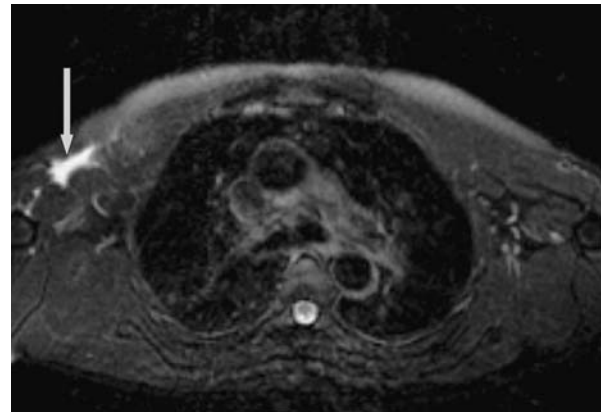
Axial T2-Fat Saturated Image of both shoulders. The discontinuity of the pectoralis muscle is seen on the right side together with the fluid collection (seroma/hematoma), which was seen with ultrasound (arrow).
